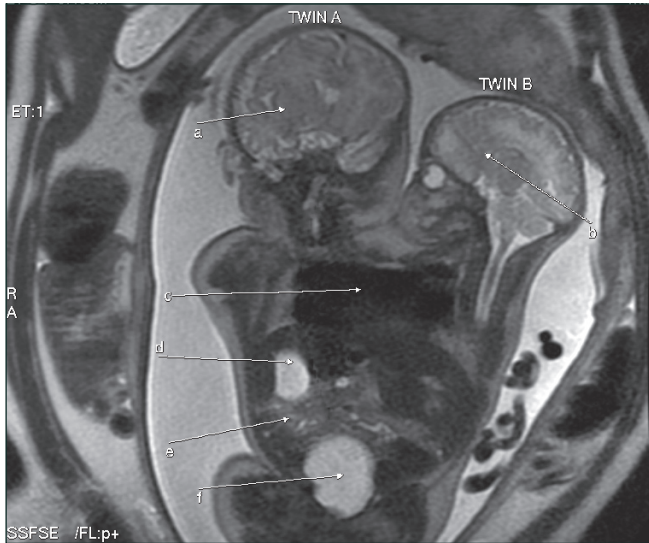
Coronal T2-weighted MRI scan. (a= brain of twin A demonstrating mature grey-white matter differentiation; b = twin B on the right in a sagittal position looking at twin A; c = the complex conjoined (multichambered) heart; d = high signal from stomach of twin A; e = horseshoe kidney of twin A; f = high signal in the pelvis from single full bladder).
